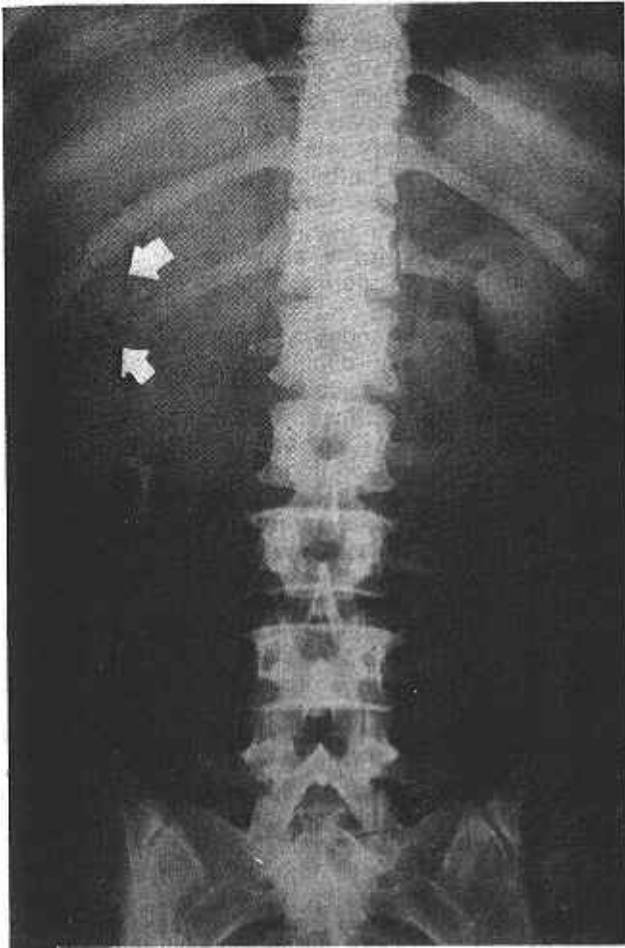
Plain film showing perinephric gas.
